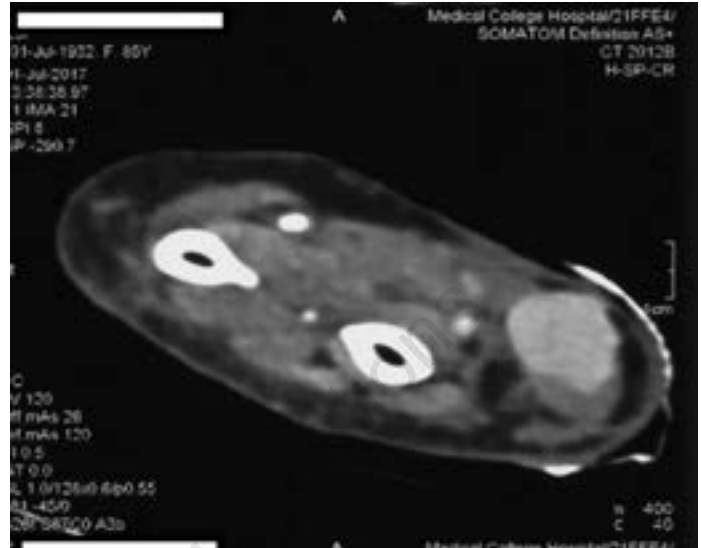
The cut section of the forearm seen on CT angiogram. Note the dilated structure filled with contrast; this was the pseudoaneurysm. A clot is seen in this section outlining the pseudoaneurysm.
